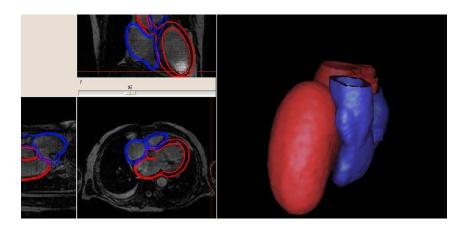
Segmentation of the left heart (in red) and the right heart (in blue) from clinical MRI.
